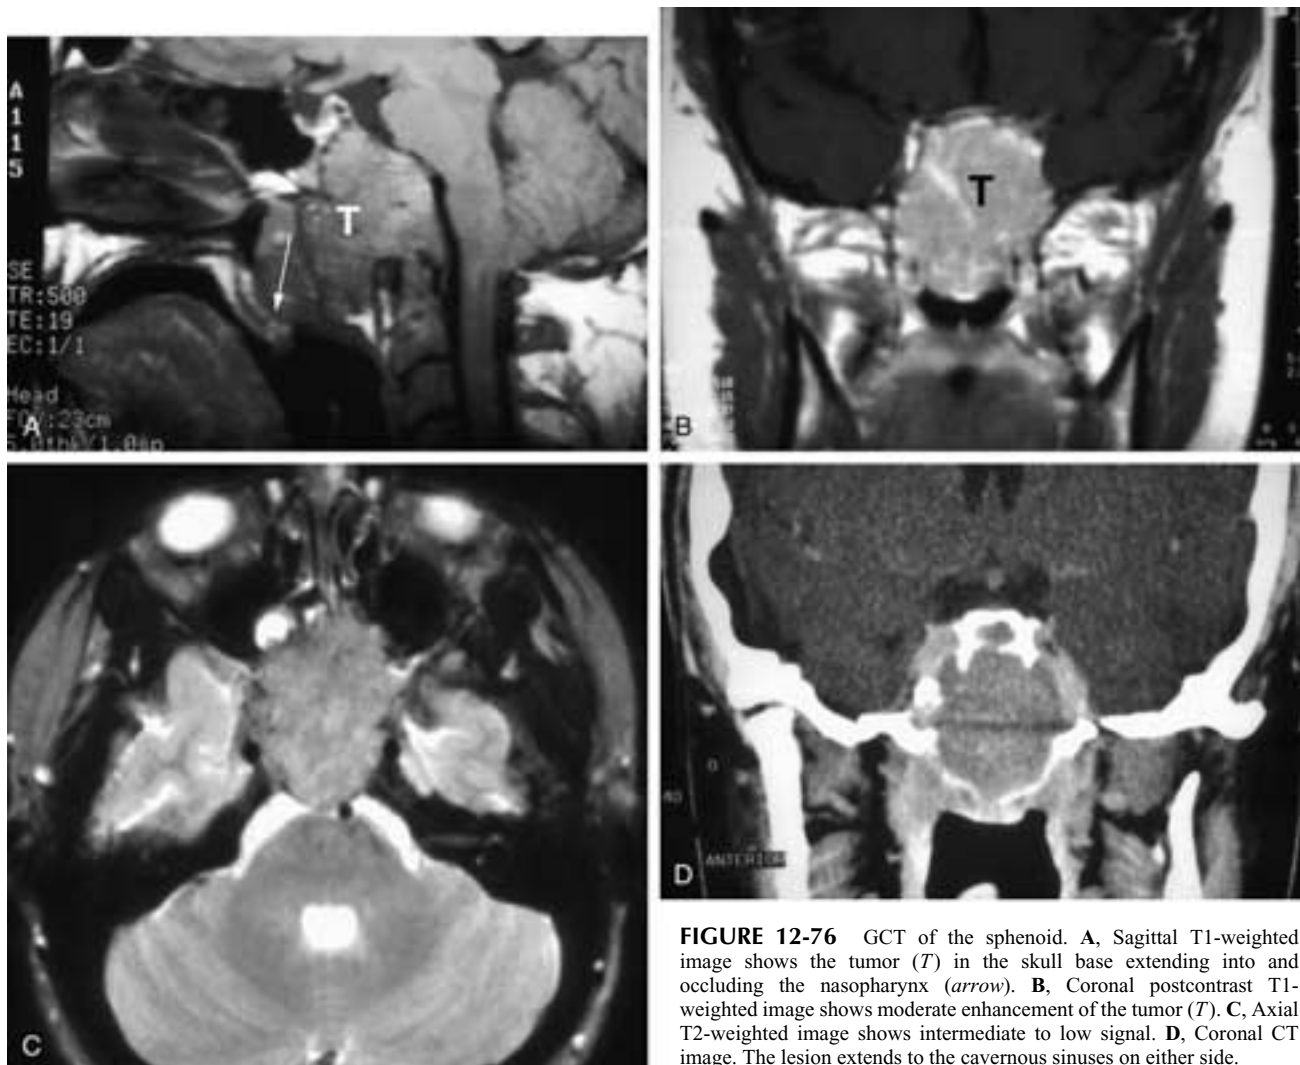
GCT of the sphenoid. A, Sagittal T1-weighted image shows the tumor (*T*) in the skull base extending into and occluding the nasopharynx (*arrow*). B, Coronal postcontrast T1-weighted image shows moderate enhancement of the tumor (*T*). C, Axial T2-weighted image shows intermediate to low signal. D, Coronal CT image. The lesion extends to the cavernous sinuses on either side.
